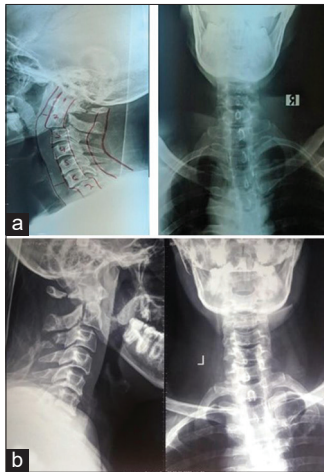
(a) Pre-Gardner-Wells tong X-ray; (b) post-Gardner-Wells tong X-ray
